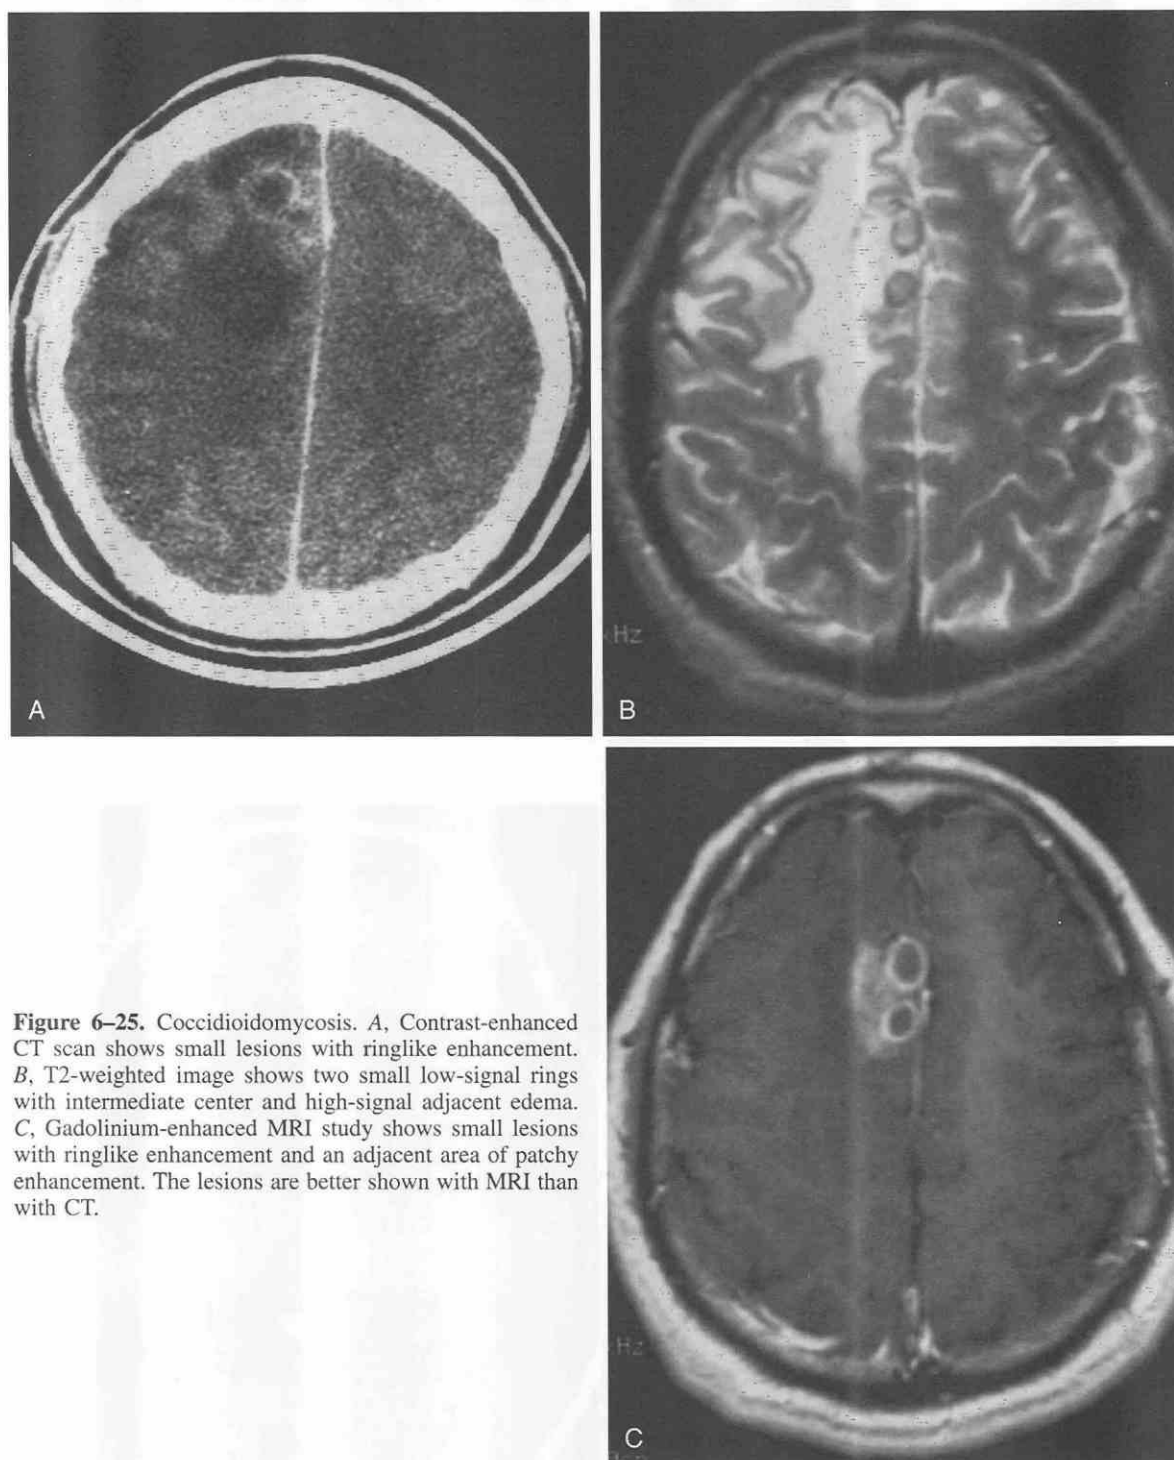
Coccidioidomycosis. *A*, Contrast-enhanced CT scan shows small lesions with ringlike enhancement. *B*, T2-weighted image shows two small low-signal rings with intermediate center and high-signal adjacent edema. *C*, Gadolinium-enhanced MRI study shows small lesions with ringlike enhancement and an adjacent area of patchy enhancement. The lesions are better shown with MRI than with CT.
